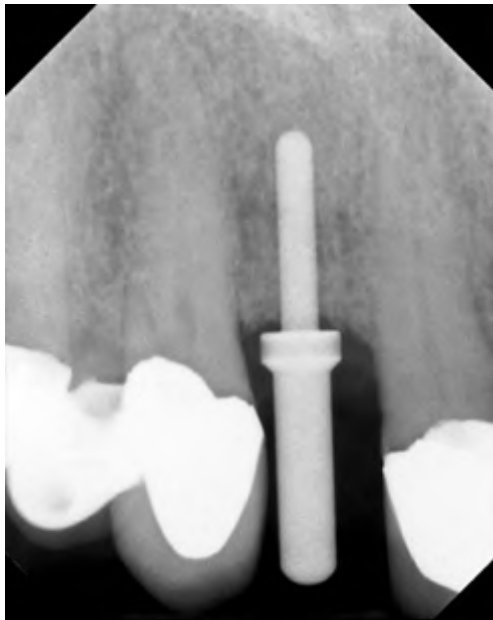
Periapical radiograph of the maxillary right lateral incisor edentulous site with the direction indicator in place. This radiograph was taken after the first drill was used and identified the orientation of the osteotomy.
